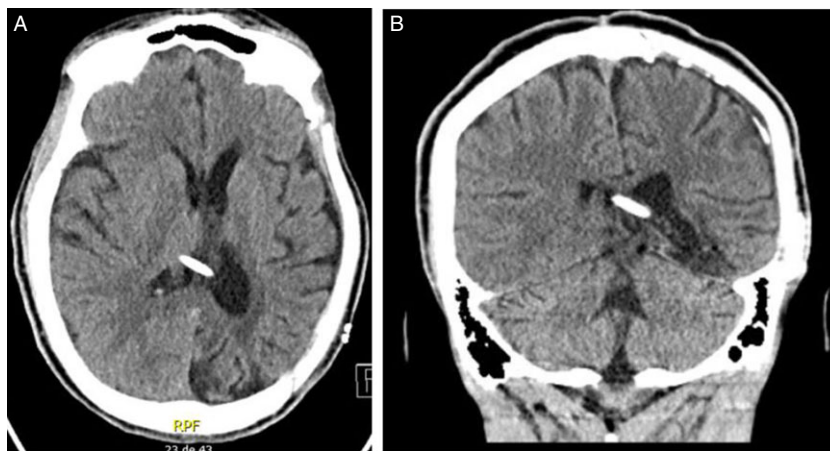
(A) Axial and (B) coronal non-contrast head CT of a 39-year-old patient with syndrome of the trephined after ventriculoperitoneal shunt ligation followed by cranioplasty showing reestablished cranial flap alignment and ventricular re-expansion and resolution of epidural hematoma.
